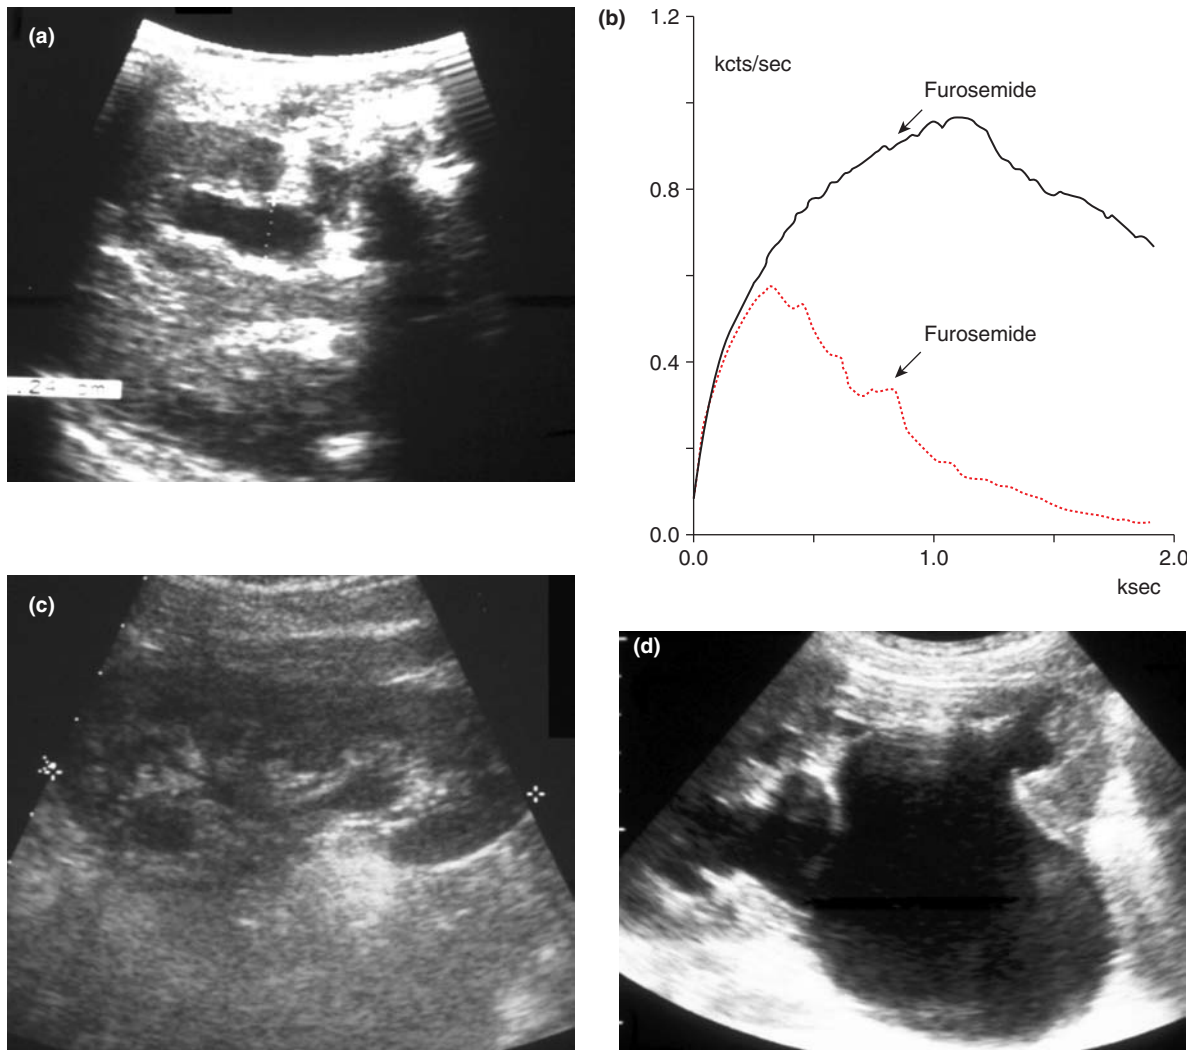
Unpredictable natural history of PUJ obstruction. (a) An ultrasound at 1 month of age. Appearance suggestive of PUJ obstruction – with good thickness renal cortex, AP diameter of renal pelvis (not shown) 18 mm. Conservative management was adopted. (b) Follow-up MAG3 study at 36 months showing type 3a O'Reilly curve (non-obstructed). Conservative management was maintained. (c) Ultrasound at 4 years of age. Complete resolution of dilatation, normal appearances of kidney. The child was discharged from further follow-up. (d) At 9 years of age he represented acutely with pain and infection. This ultrasound scan demonstrates severe dilatation due to recurrent PUJ obstruction. Pyeloplasty was curative.
